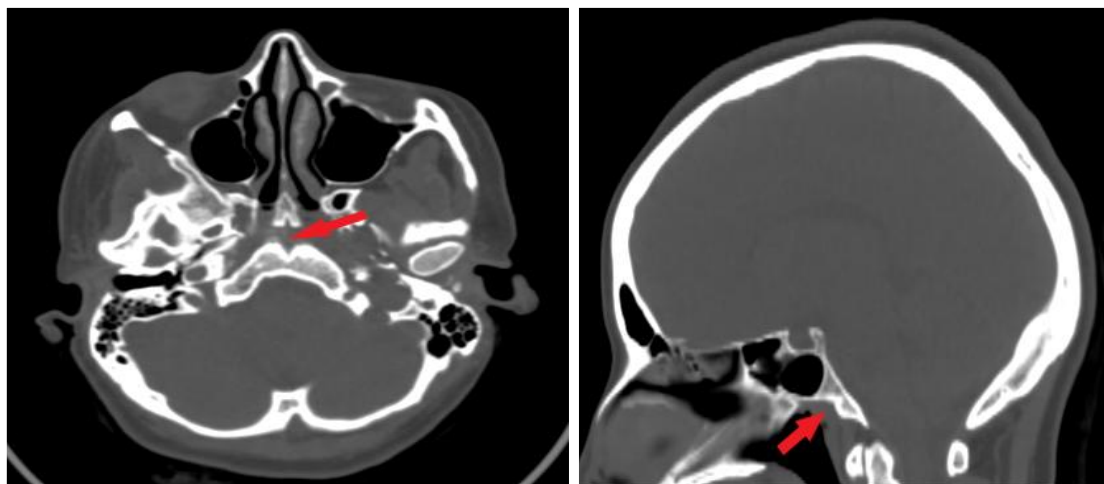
CT image axial & sagittal view shows a case with fossa navicularis.
